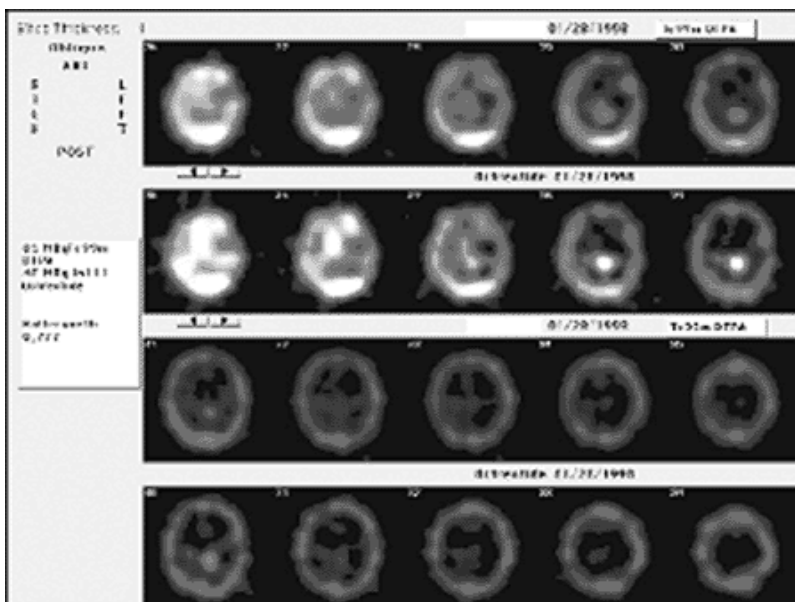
In-111-octreotide SPECT examination in a child with a neuroendocrine active brain tumor (PNET), transversal tomograms (E.CAM). Row 1 and 3: disturbance of blood
